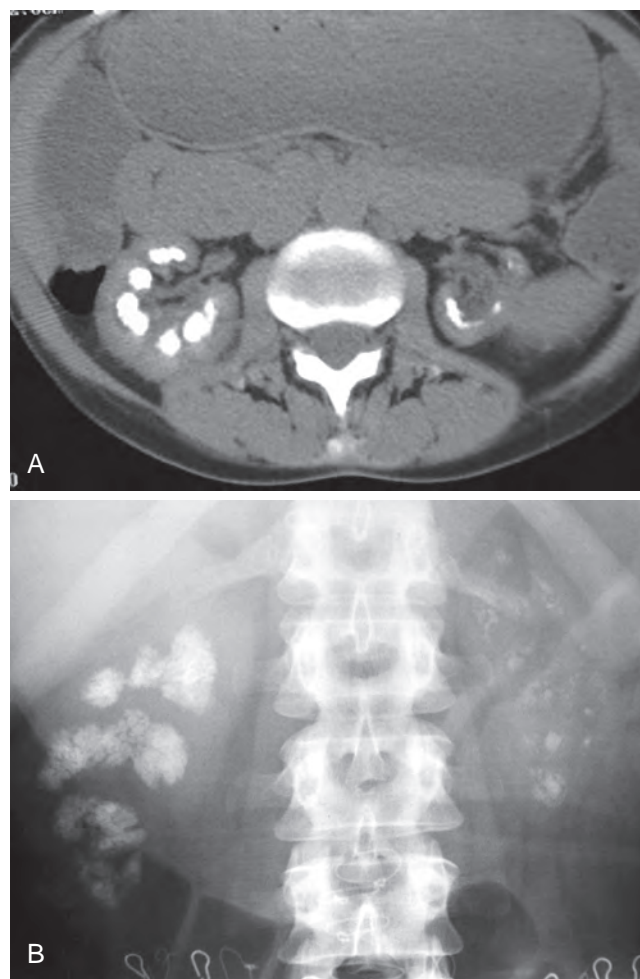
Computed tomography (CT) (A) and plain film (B) of a patient with renal tubular acidosis and renal failure. Both kidneys demonstrate severe calcification of the medullary pyramids consistent with nephrocalcinosis. Note the atrophic left kidney on the CT image (A).
